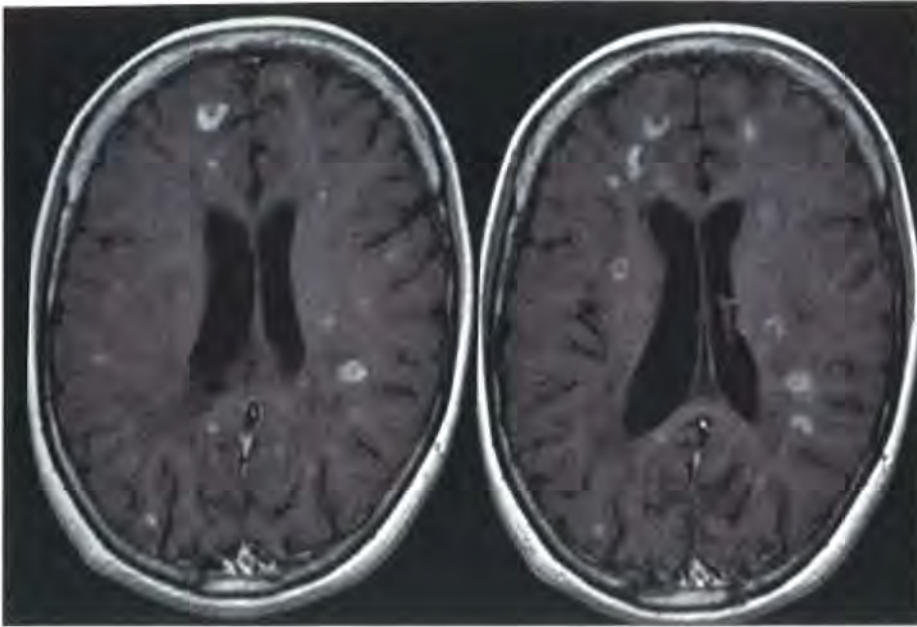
Gadolinium enhanced T_1 -weighted MRI in clinically definite multiple sclerosis. This patient has >100 enhancing lesions at this time.
